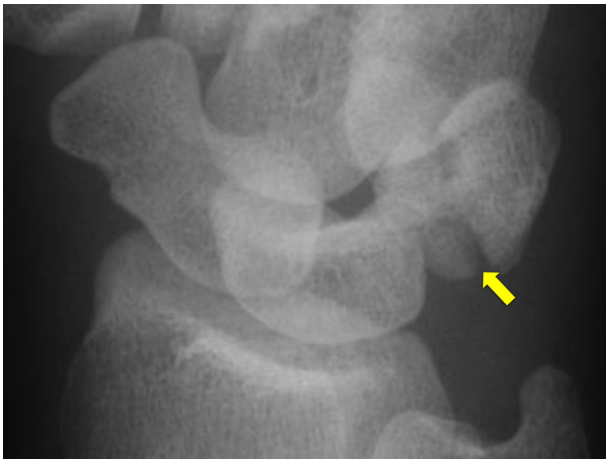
Plain radiograph demonstrating a triquetrum fracture (arrow).
